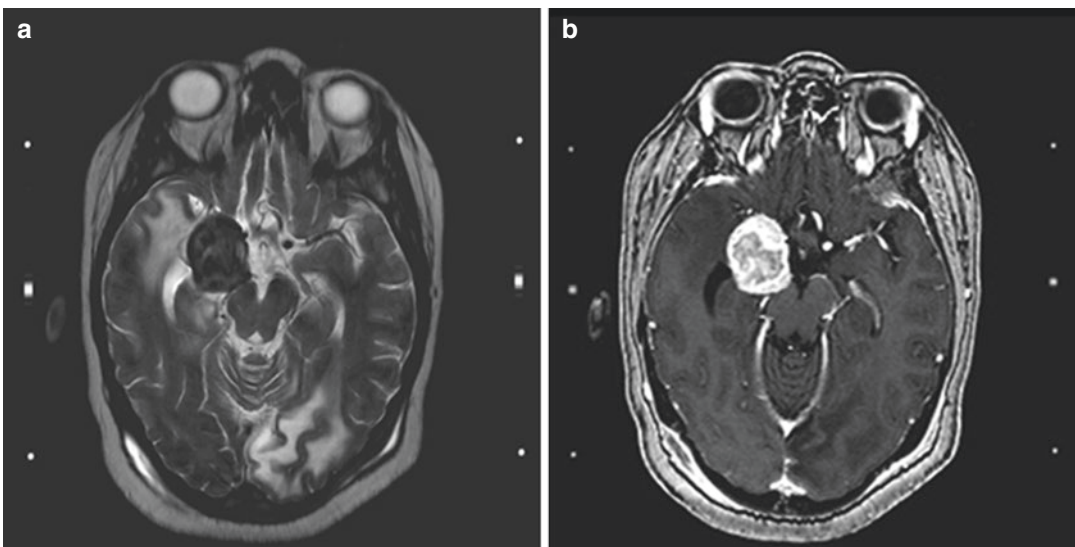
MRI: melanotic pattern of brain metastasis in patient with melanoma on T2 (a) and T1p/c (b) images
